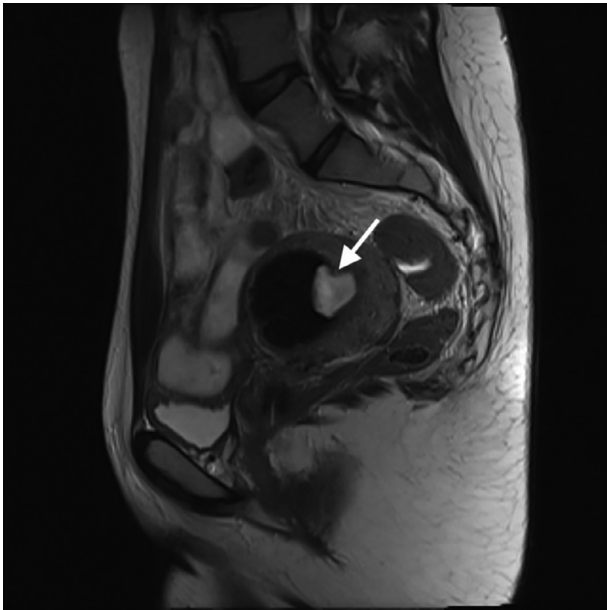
Postembolization state (2018) T2-weighted MRI sagittal view shows decreased size of myoma and connection to endometrium compare to Figure 2.
